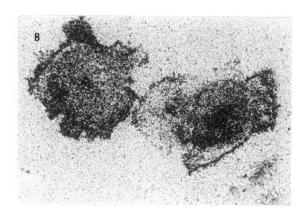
Monocyte/UMR106.01 coculture after 14 days incubation showing: (a). Multinucleated cells positive for TRAP (x 200). (b). the presence of CT receptors on multinucleated cells by autoradiography using ¹²⁵I labelled CT (x 400).
